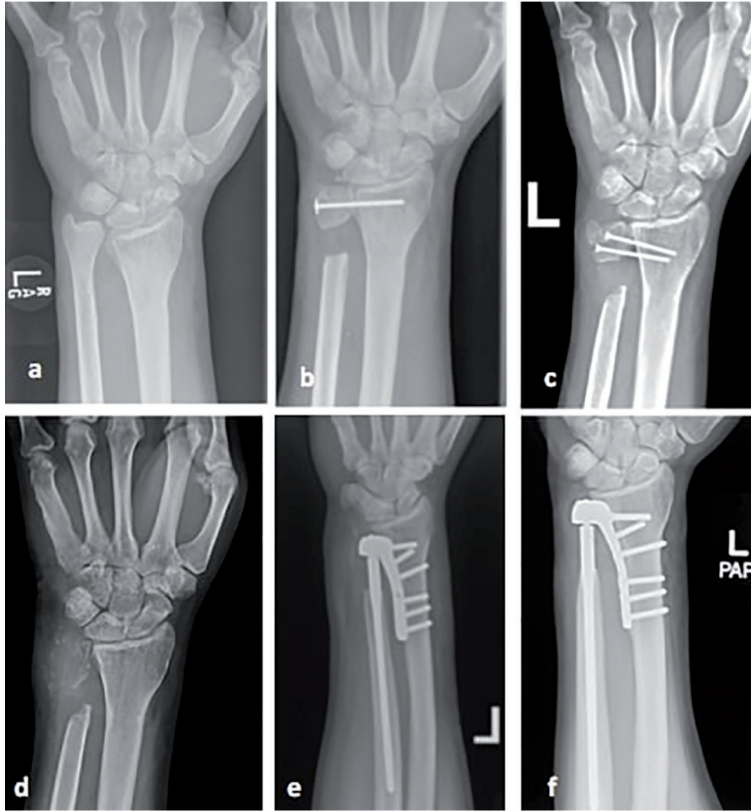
Radiographs of patient who underwent 6 reoperations.
